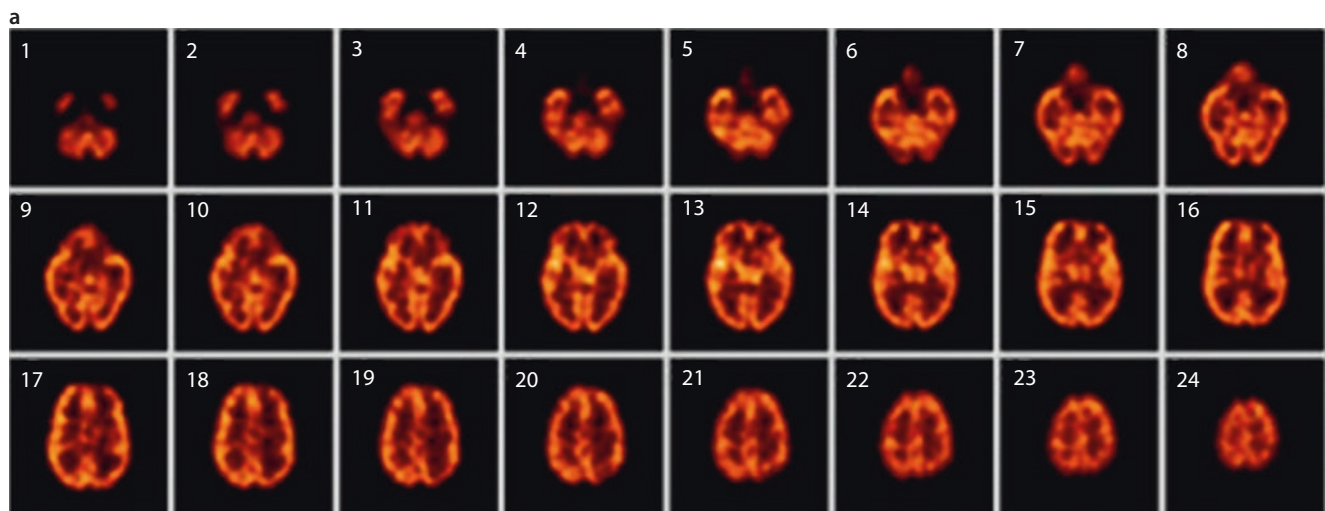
a Standard SPECT rCBF study, as acquired in a general nuclear medicine center
